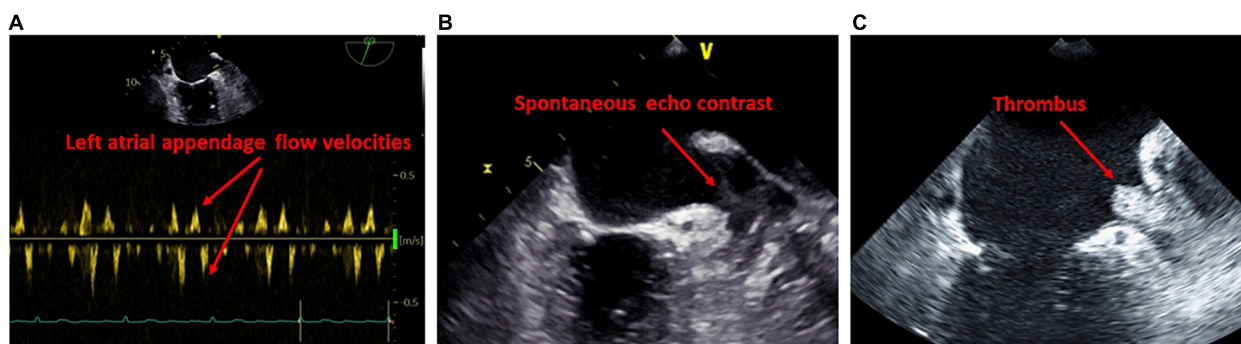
Findings on transesophageal examination suggestive of left atrial cardiomyopathy. (A) Reduced blood flow in the ostium of the left atrial appendage. (B) Evidence of spontaneous echo contrast in the left atrial appendage. (C) Evidence of thrombus in the left atrial appendage.
